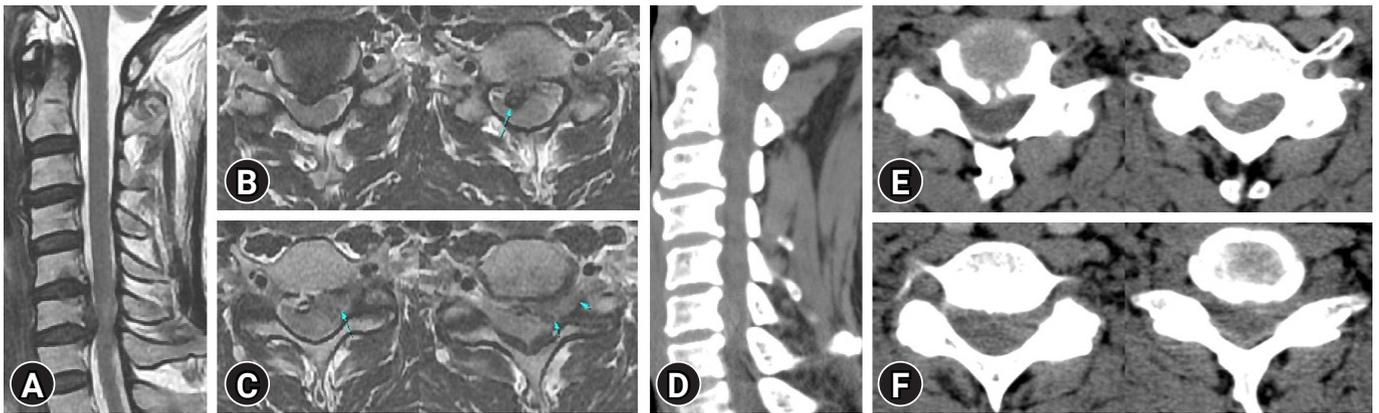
Preoperative images of the up migrated cervical disc herniation at C5-6, C6-7 level on MRI and CT. (A) A mid-sagittal image on T2 weighted MRI. (B) Axial images at C5-6 level on T2 weighted MRI. (C) Axial images at C6-7 level on T2 weighted MRI. (D) Mid-sagittal images on CT. (E) Axial images at C5-6 level on CT. (F) Axial images at C6-7 level on CT.
